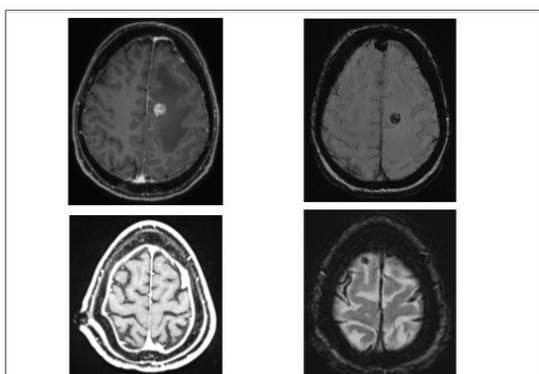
Top: Melanoma metastasis on T1 MRI (left) and SWI (right). The frontal SWI change is falcine calcification. Bottom: The SWI signal change (right) has no T1 correlate (left) and represents postoperative blood.
